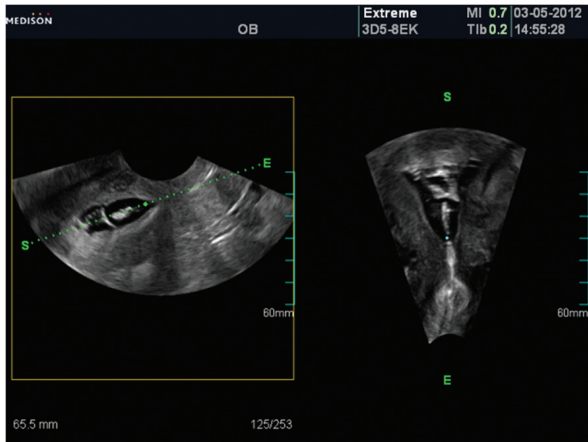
shows an ultrasound scan of a patient with AS showing a mixed picture of the endometrial line; however, the line in some parts cannot be visualized, while in other parts, the endometrium appears normal. Other appearances are adhesions, which are observed as endometrial irregularities (17). Intrauterine adhesions (IUA) appear either as eccentric echogenic or as calcificated areas in ultrasound. Endometrial thickness may be with or without focal multi cystic. If the canal is completely obliterated, there is an absent endometrial stripe in ultrasound (US) finding (4).
